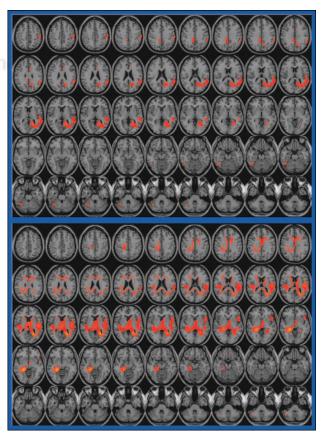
99mTc-HMPAO SPECT elucidated characteristic patterns of cerebral perfusion in patients with Alzheimer's disease (top) and with early-stage subcortical vascular dementia (bottom) using statistical parametric maps. Such techniques promise to provide valuable information in directing patients with dementias to appropriate treatments.
